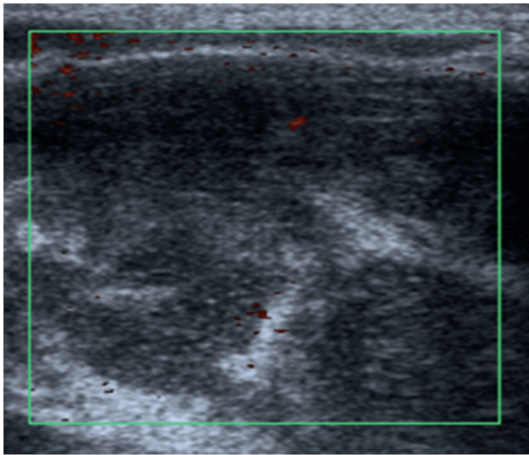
Preoperative ultrasonography image revealing fluid content of the inflammatory reaction.
